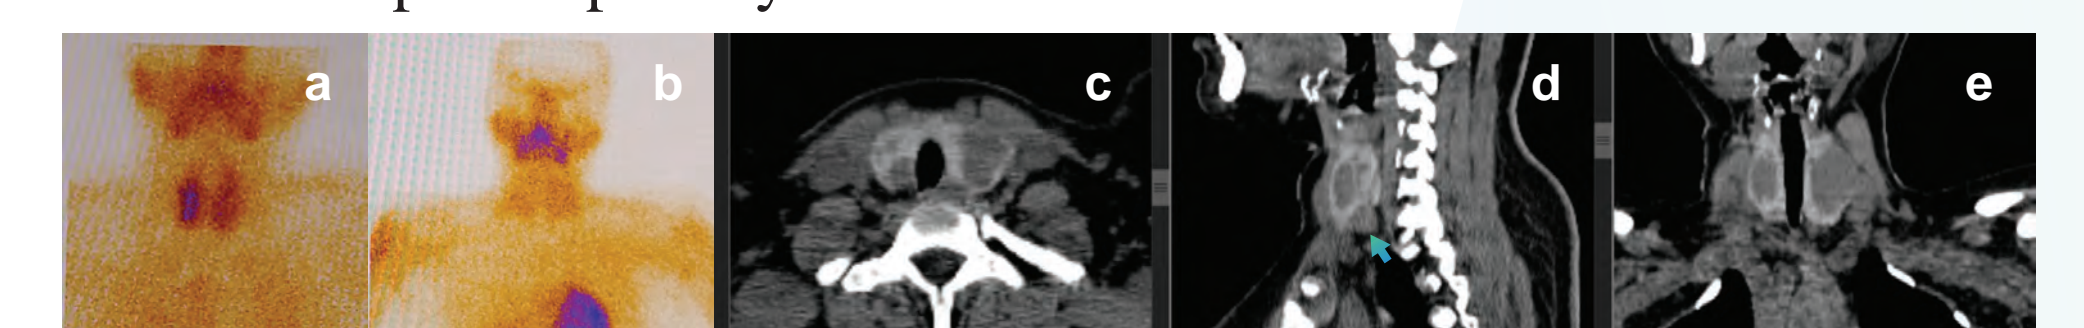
(a, b) ^{99m}Tc-MIBI Parathyroid scan was negative for parathyroid adenoma. (c-d) CT images showing thyroid nodules and suspected parathyroid adenoma (arrow).
